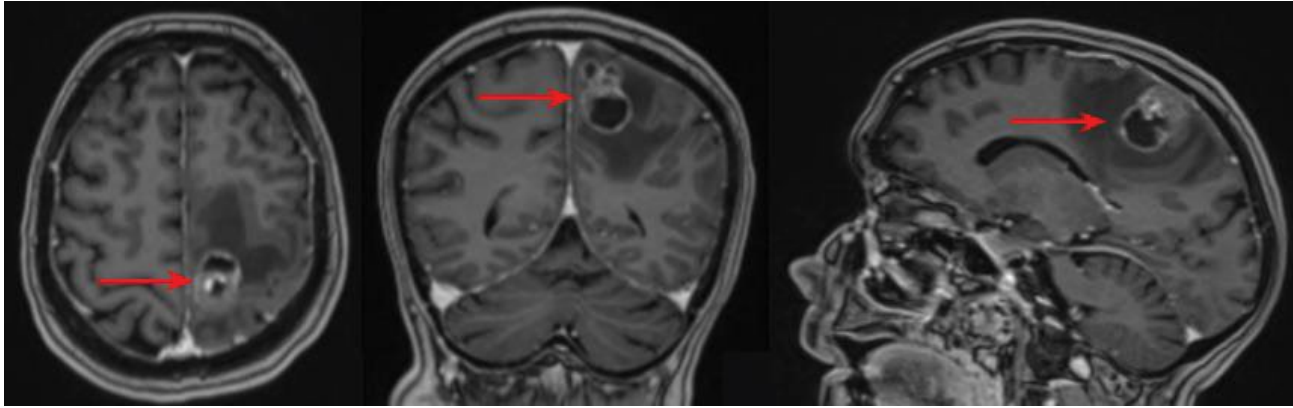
Preoperative MRI, T1 gadolinium-enhanced sequence. The tumor is marked with the red arrows.
